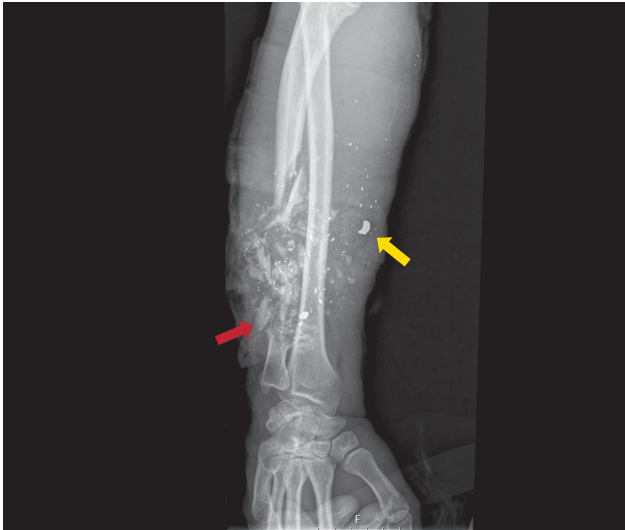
Radiograph of the right forearm, at admission. Yellow arrow: metallic fragment; red arrow: bone fragment.
